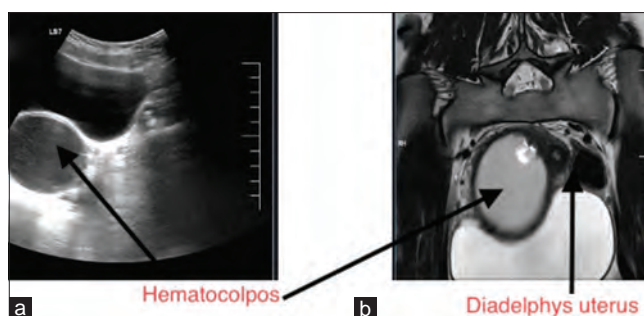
(a) Ultrasound showing hematocolpos and (b) magnetic resonance imaging showing obstruction in lower limit of the vagina
